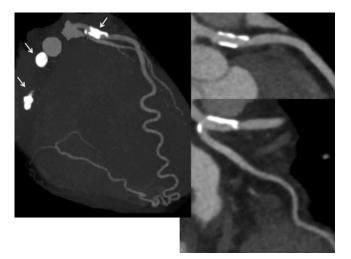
CT coronary angiograms (Patient 2). (Left) An occlusion of the right coronary artery and coronary artery calcification at segments 1, 2, 4, 6, and 11 were detected. The collateral arteries from the left anterior descending artery to the posterior descending artery were well developed (Right upper). The angiogram revealed calcification at segment 6 of the left anterior descending artery (Right lower). The angiogram also revealed calcification at segment 11 of the left circumflex.
